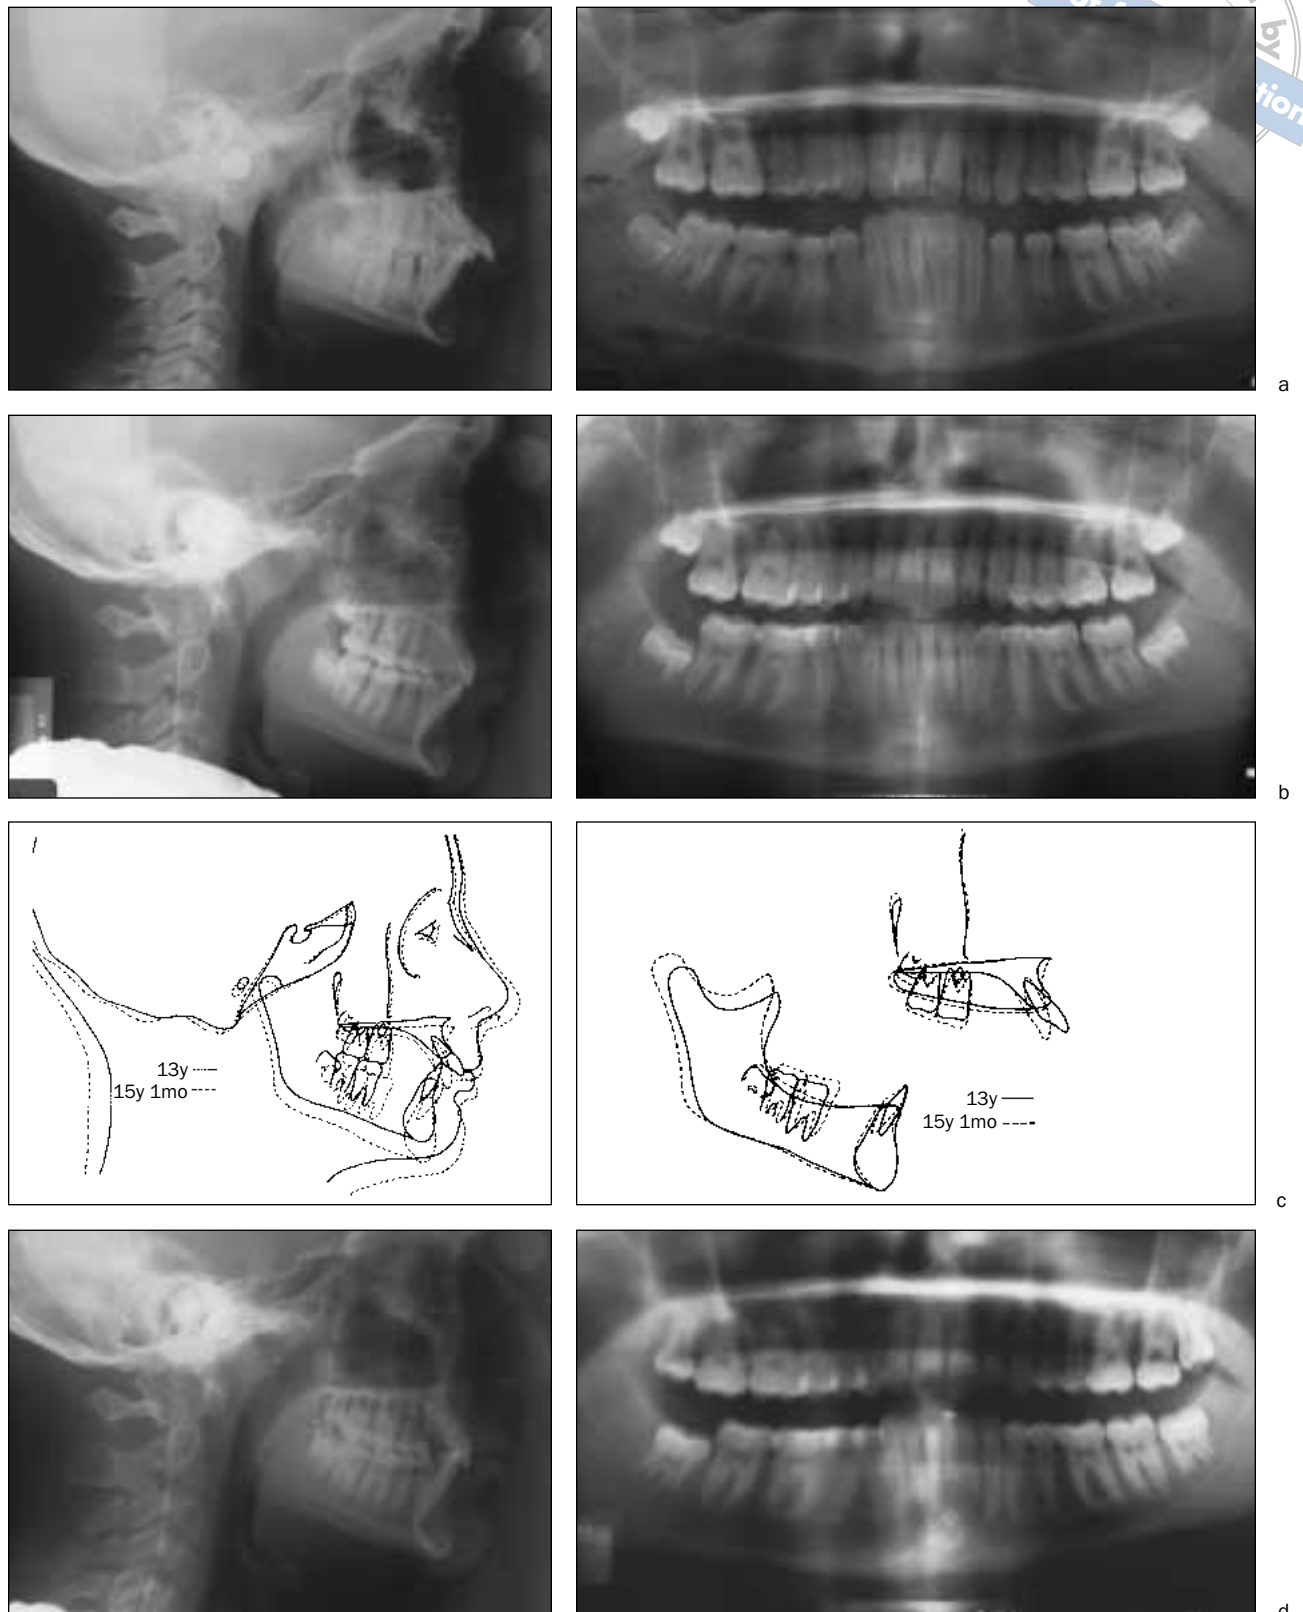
Case 2. (a) Pretreatment cephalogram and panoramic radiograph. The ODI was 79 degrees and APDI was 70 degrees, indicating a Class II deep overbite skeletal pattern. (b) Posttreatment cephalogram and panoramic radiograph show a satisfactory result. (c) Posttreatment cephalometric superimposition reveals that the maxilla and the mandible grew downward. (d) Cephalogram and panoramic radiograph, taken 27 months posttreatment, when the patient was 17.5 years of age.
